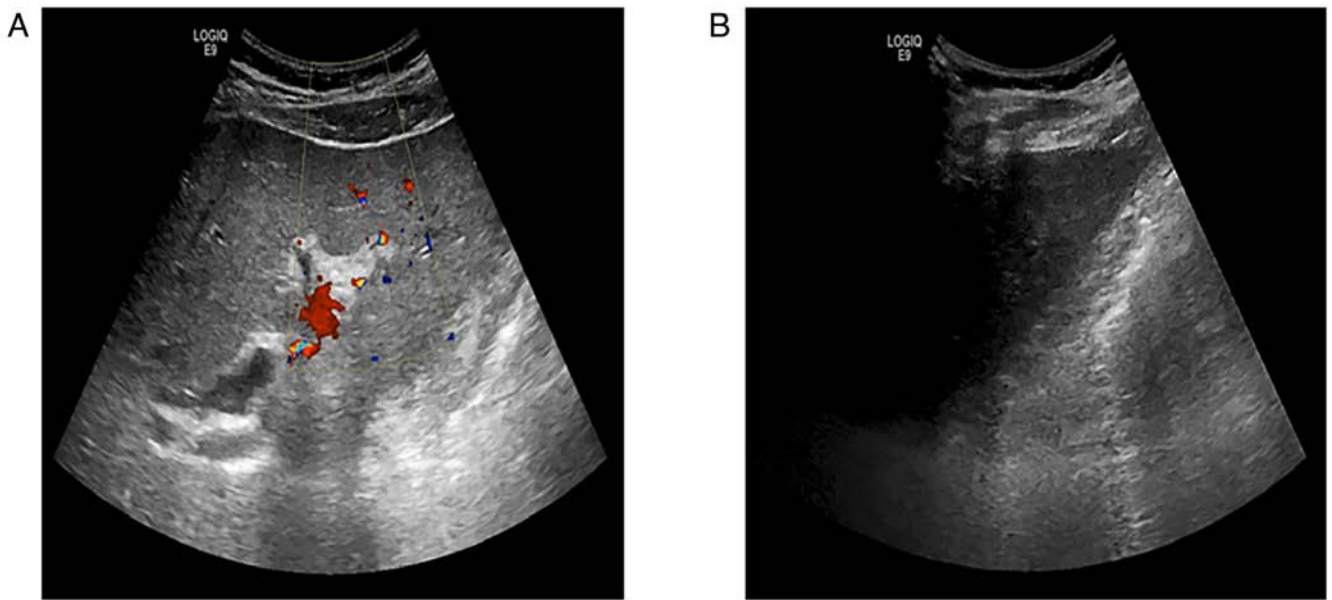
(A and B) Observations from color Doppler ultrasonography of the abdomen. (A) Enhanced liver parenchyma echo and thick light spot were observed, indicative of cholestatic liver disease and the intrahepatic and extrahepatic biliary systems were extensively dilated, indicating the possibility of distal common bile duct obstruction. (B) Sand-like stones in the gallbladder and splenomegaly were observed.
